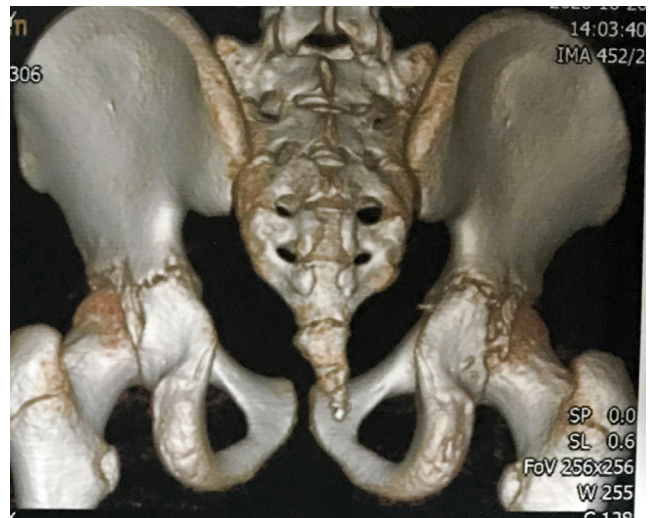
Postoperative 3D-CT demonstrated anatomical reduction of the major osseous fragment of the posterior wall.
